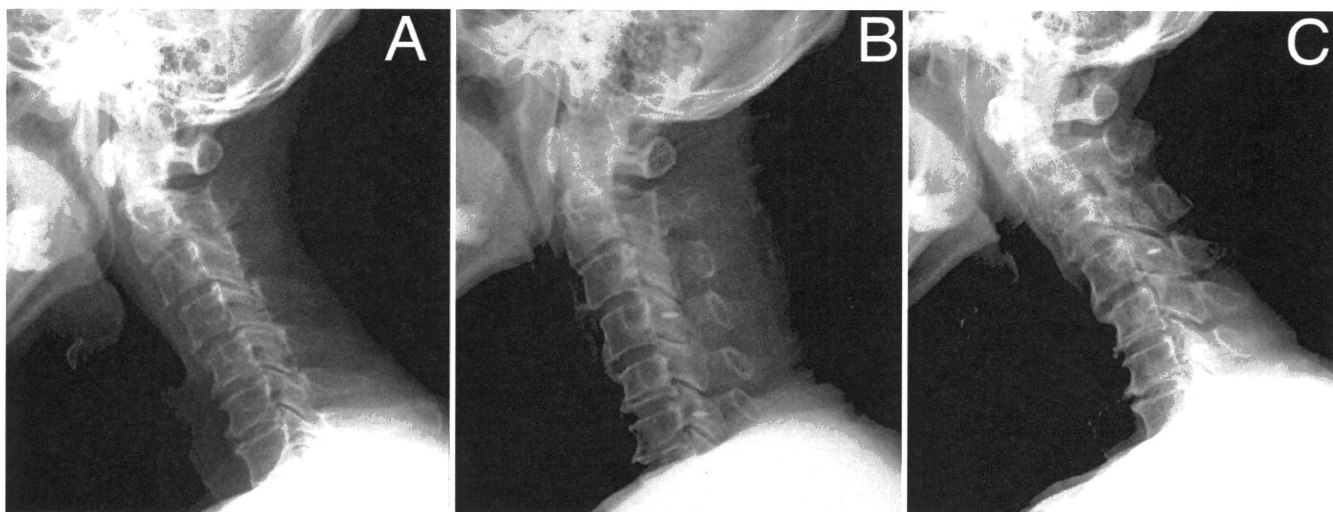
Lateral radiographs obtained in a 70-year-old man with preoperative kyphosis in whom lamina closure developed despite the use of anchor screws. This patient had cervical spondylotic myelopathy with mild cervical kyphosis before surgery. The CBR of 0.81 before surgery (A) increased to 1.35 immediately after surgery (B), and decreased to 1.10 at the final follow-up examination (C). The patient obtained moderate neurological recovery (recovery rate of 48%), but was slightly dissatisfied with his surgery.
